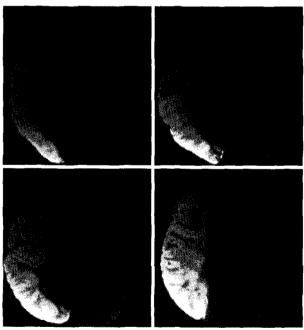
Brain diffusion magnetic resonance image taken at the time of the second attack showing diffusion restriction of the right middle cerebral artery territory.
